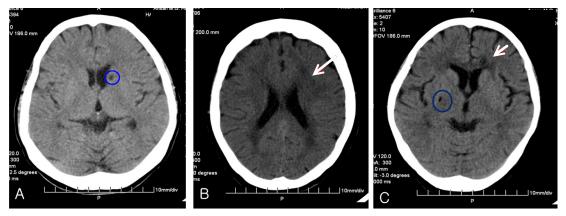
Representative examples of silent brain infarcts (SBIs, circle in A), cerebral white matter changes (WMCs, arrow in B), and both SBIs and cerebral WMCs (C) on brain CT.
